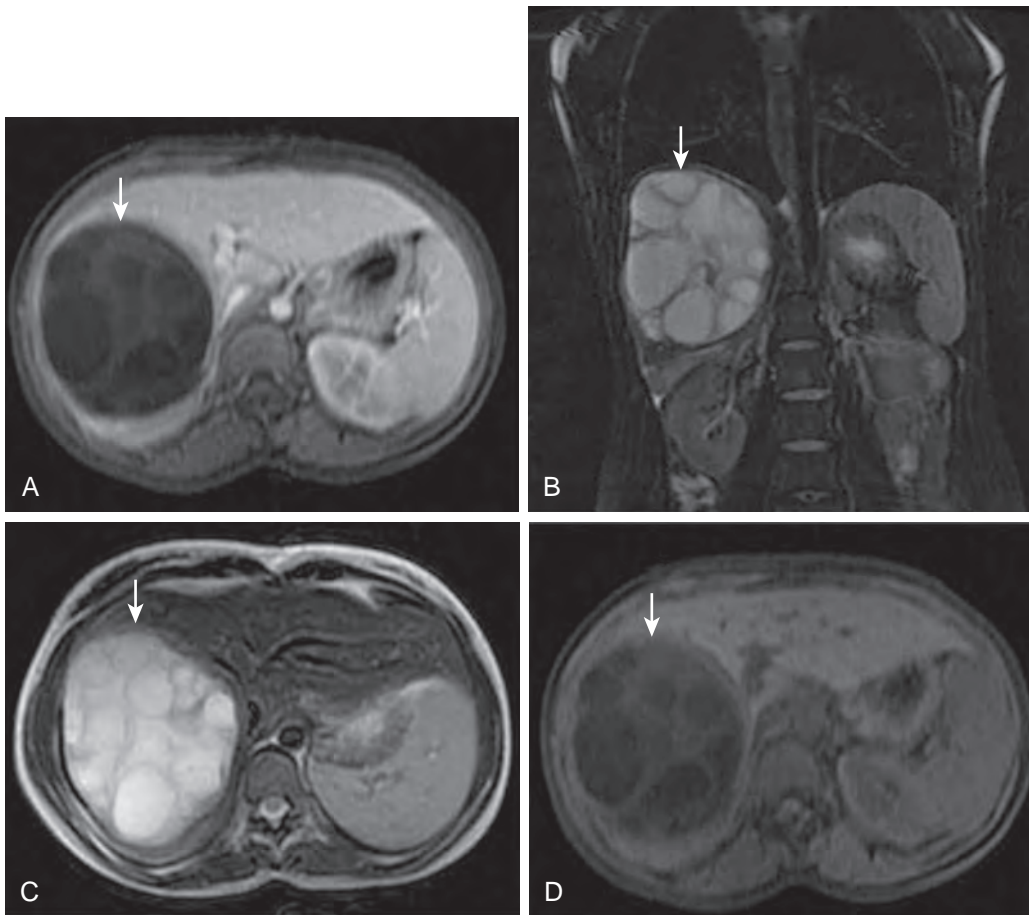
Hydatid disease: MRI features. A patient with hydatid cyst. On the coronal (A) and axial (B) T2-weighted images, the lesion (arrow) appears hyperintense and includes daughter cysts. On the T1-weighted image (C), the lesion (arrow) is hypointense and does not show any enhancement after the injection of gadolinium (D). Note that the daughter cysts are darker (arrow) on the T1-weighted images.
